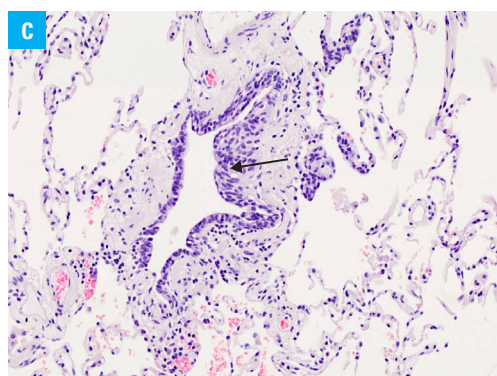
A – chest computed tomography: axial maximum intensity projection image revealing numerous, small, randomly distributed nodules (arrows); B – chest computed tomography: axial image revealing a mosaic lung pattern with air trapping (dark blue arrows) and bronchial wall thickening (light blue arrow)
